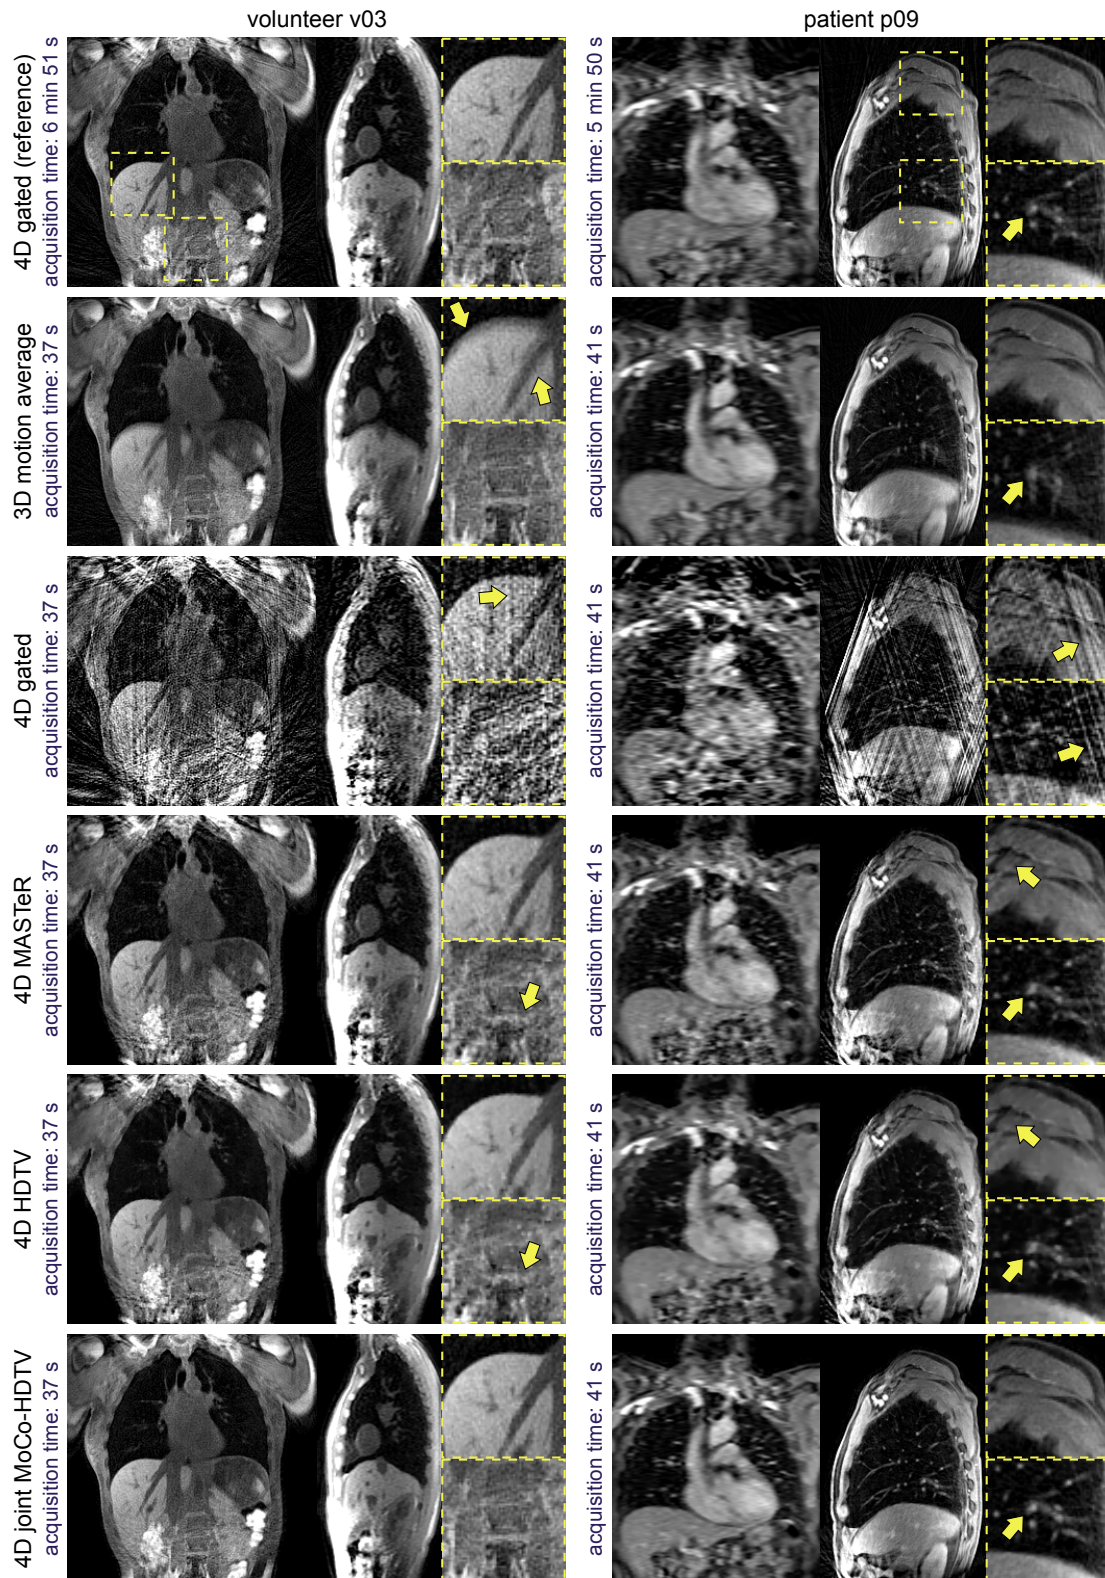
4D MRI study: MR image reconstructions of reference and highly undersampled raw data sets from a 29-year-old female volunteer (v03, left) and from a 72-year-old male patient (p09, right) in end-exhale. Images were acquired in coronal and sagittal view, respectively, and upsampled to isotropic resolution for visualization. Adopted from Rank et al. (2016a).
